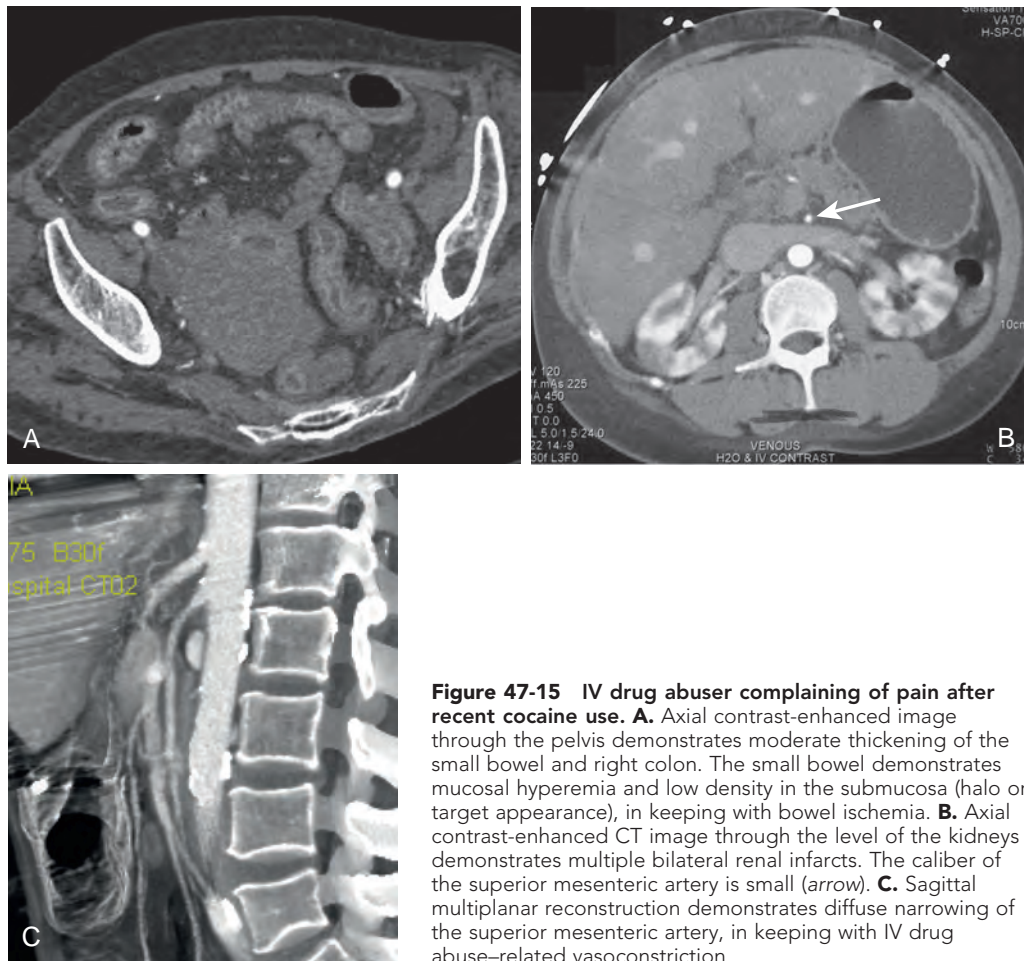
IV drug abuser complaining of pain after recent cocaine use. A. Axial contrast-enhanced image through the pelvis demonstrates moderate thickening of the small bowel and right colon. The small bowel demonstrates mucosal hyperemia and low density in the submucosa (halo or target appearance), in keeping with bowel ischemia. B. Axial contrast-enhanced CT image through the level of the kidneys demonstrates multiple bilateral renal infarcts. The caliber of the superior mesenteric artery is small (arrow). C. Sagittal multiplanar reconstruction demonstrates diffuse narrowing of the superior mesenteric artery, in keeping with IV drug abuse-related vasoconstriction.
